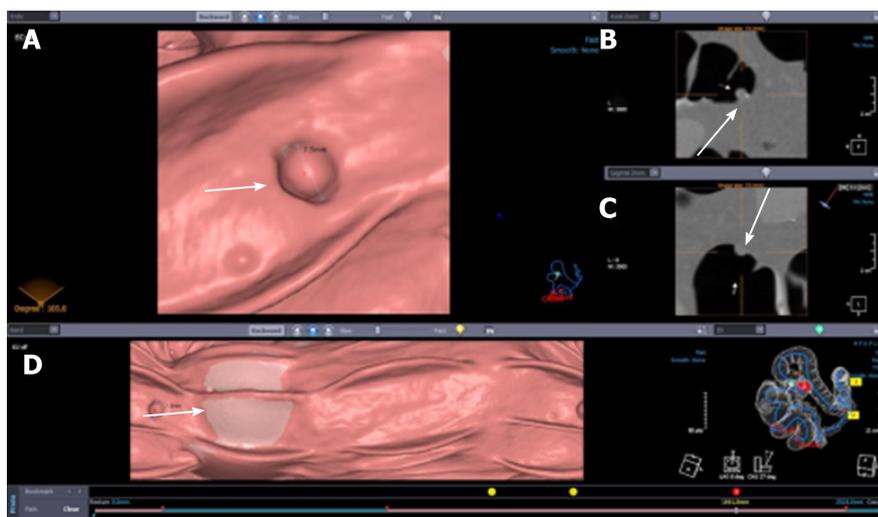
Computed tomography colonography: Two- and three-dimensional view of the polyp (arrows). A: Polyp 3D view; B: Polyp 2D view; C: Polyp 2D view; D: Tagged stool.
